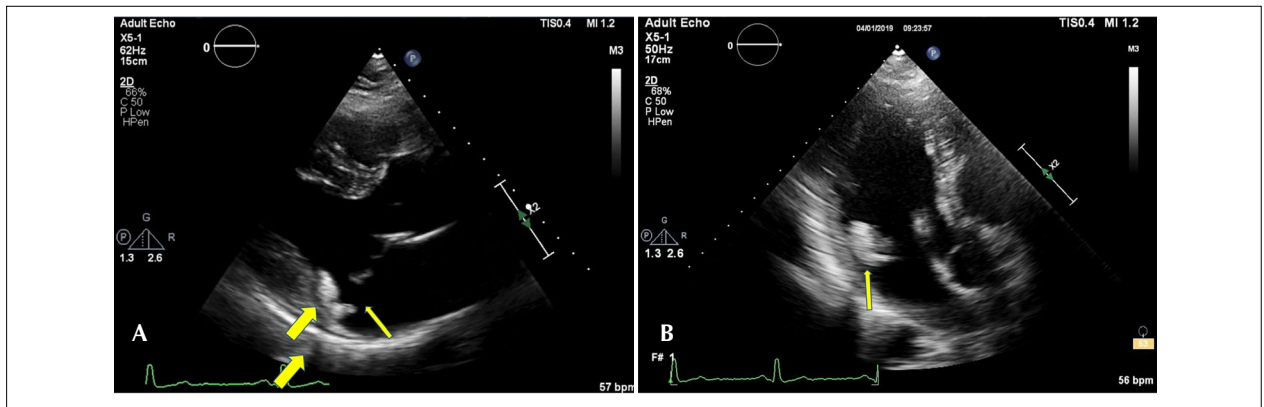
Patient with mitral valve prolapse and calcification of part of the posterior portion of the valve annulus. A. The parasternal longitudinal plane showing mitral valve prolapse (thin arrow) and calcification of the valve annulus with formation of posterior acoustic shadow (thick arrows). B. The apical three-chamber plane showing calcification of the valve annulus (thin arrow).
